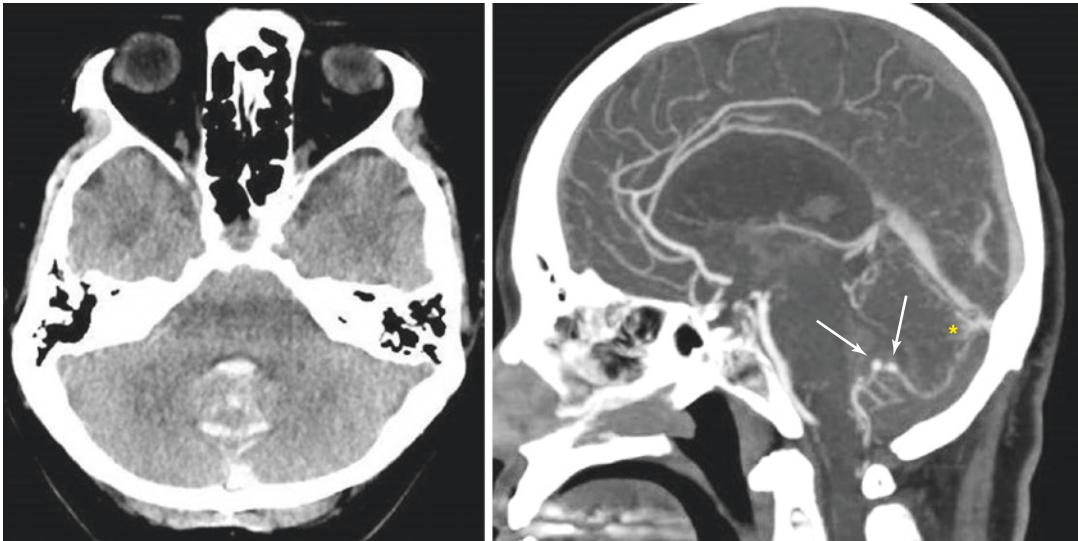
CASE 3. Dural AVM with presumed feeding artery aneurysm bleed in a 72-year-old woman presenting with severe headache, meningism, and somnolence. Initial CT shows subarachnoid and intraventricular blood (left).
